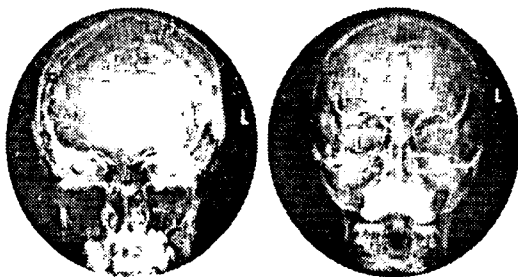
Figures and Radiographs courtesy of Ballinger & Frank Merrile Atlas of Radiographic Positions and Radiologic Procedures and Bontrager Radiographic Positioning and Related Anatomy.
